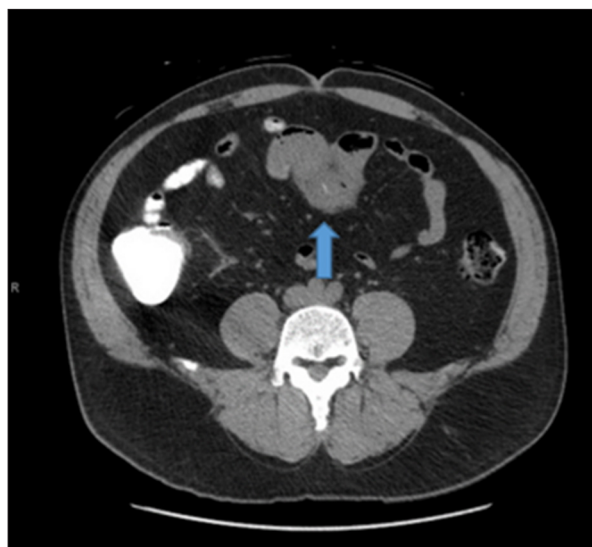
Case 1 – CT scan abdomen and pelvis demonstrating a metallic foreign body within the small bowel (blue arrow).
